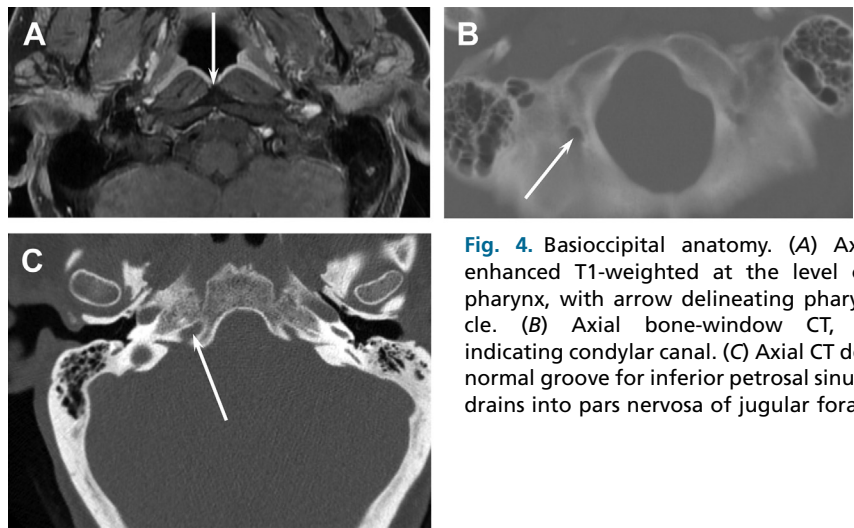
Basioccipital anatomy. (A) Axial contrast-enhanced T1-weighted at the level of the nasopharynx, with arrow delineating pharyngeal tubercle. (B) Axial bone-window CT, with arrow indicating condylar canal. (C) Axial CT demonstrating normal groove for inferior petrosal sinus (*arrow*) as it drains into pars nervosa of jugular foramen.
